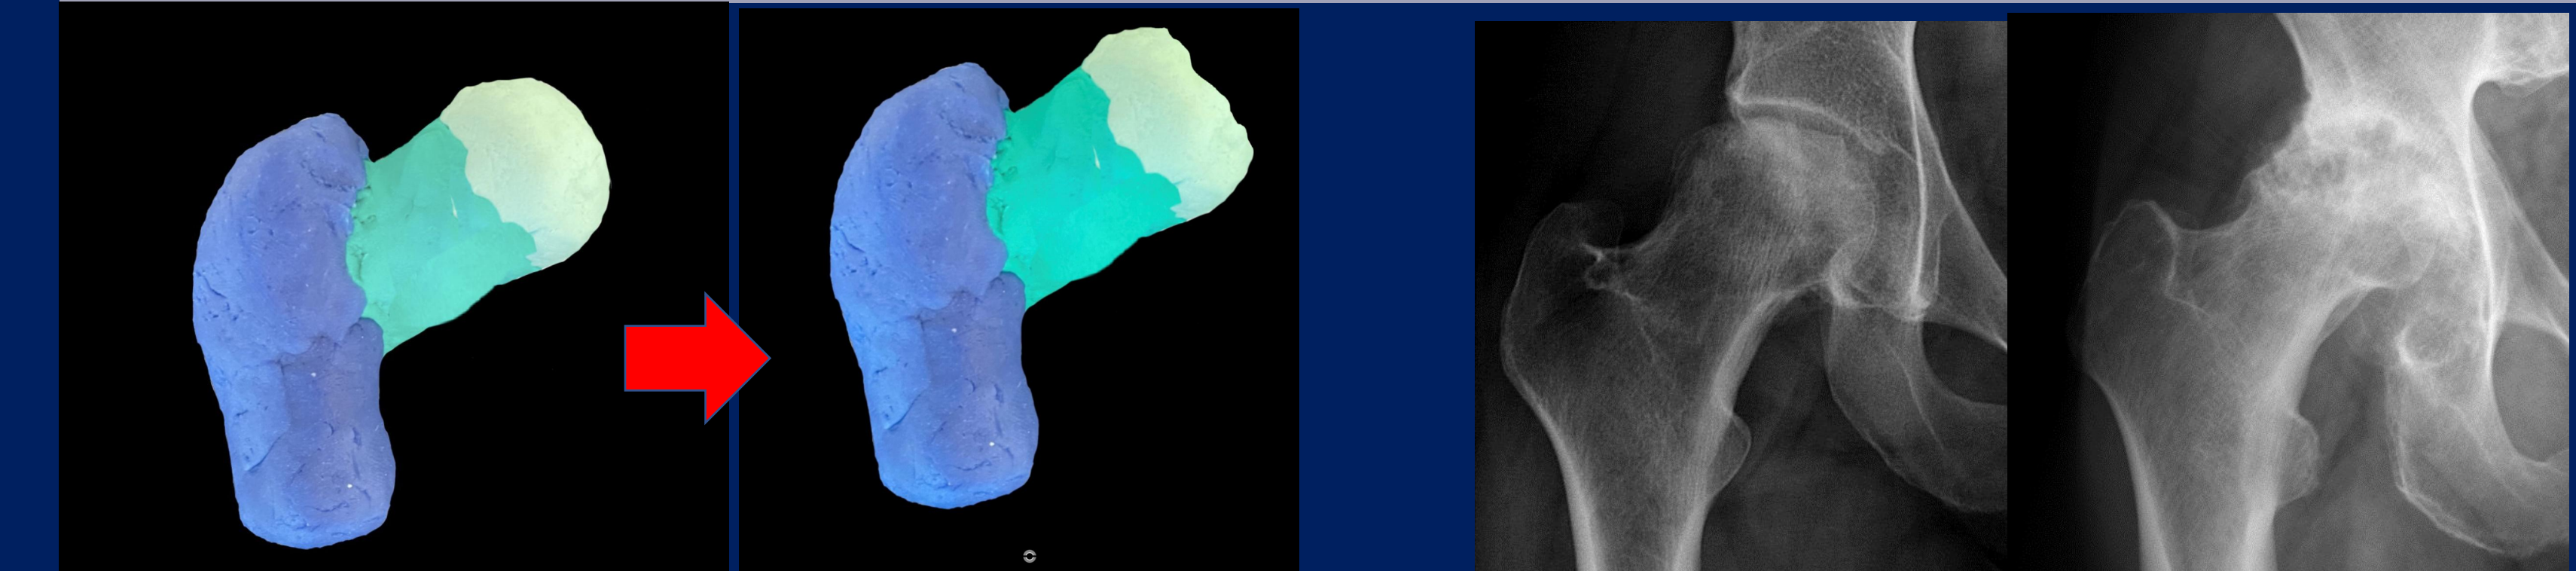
Clay model of the normal hip (left) and femoral head avascular necrosis (AVN) deformity (middle left). Two frontal radiographs of the right hip in different patients (middle right and right) demonstrating deformity of the femoral heads with sclerosis, lucencies, and significant joint space loss (right) consistent with AVN (red circles).
